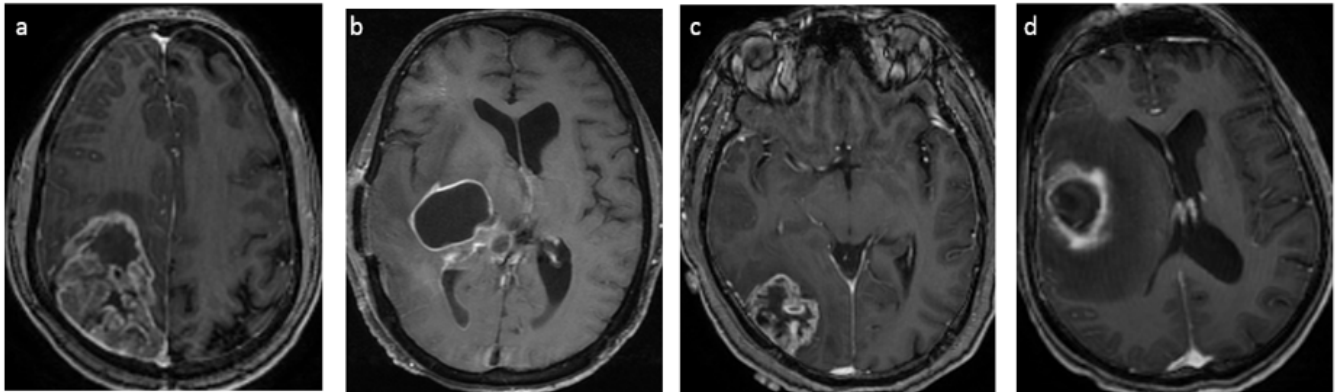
MRI post-gadolinium images of various grade IV GBM with hypermethylated and unmethylated *MGMT*. Imaging features showing: (a) mixed-nodular in a patient with hypermethylated *MGMT* and (b) ring enhancement in unmethylated *MGMT*. Another two cases demonstrating (c) preferential location of grade IV GBM with hypermethylation of the *MGMT* promoter located in parietal and occipital lobes, and (d) unmethylated of the *MGMT* promoter in the temporal lobes. GBM, glioblastoma multiformes; *MGMT*, *O*₆-methylguanine-DNA-methyltransferase.
